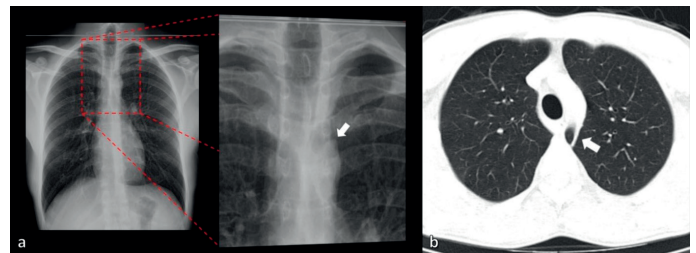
Posteroanterior (PA) chest radiograph (a) shows the “aortic nipple” sign due to a dilated left superior posterior intercostal vein (white arrow). Axial thoracic CT (b) demonstrates a left azygos lobe formed by medial entrapment of the left upper lobe.
